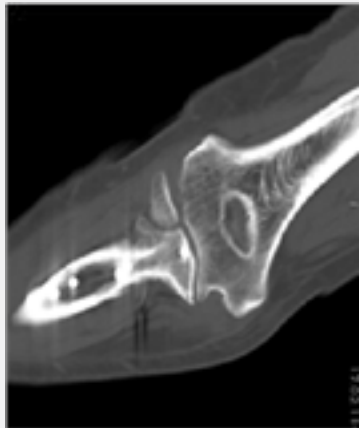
CT scan at 3y post op showing adequate bone healing and acceptable ulnohumeral congruency and the most proximal screw from the distal fragment to be extraarticular
